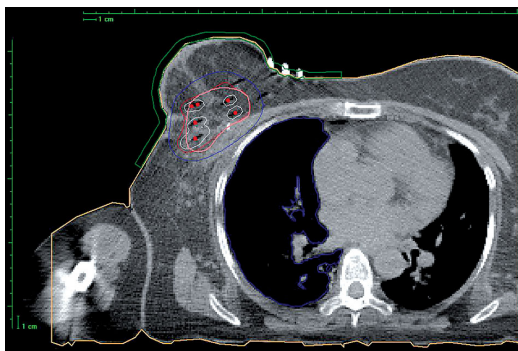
The distribution of dose (isodoses) obtained after the preparation of the treatment plan, target CT cross-sections performed every 2-3 mm
